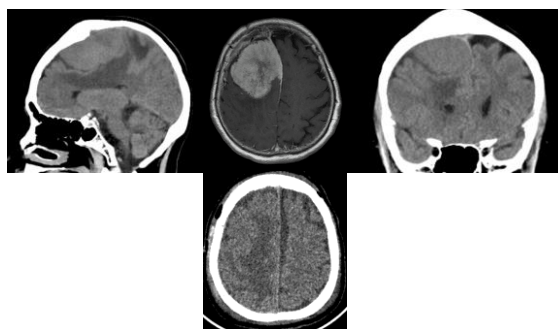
Pre-operative and post-operative imaging comparison in sagittal, axial, and coronal views for case 3. The pre-operative axial view was obtained using contrast MRI, while the remaining images were acquired using non-contrast CT scans.
